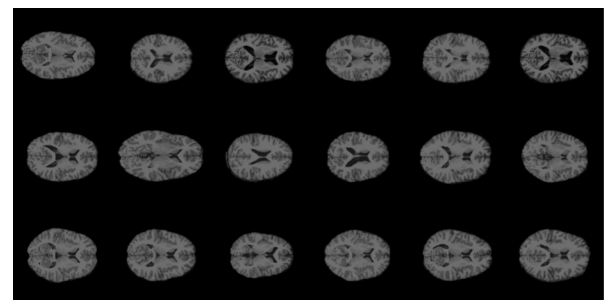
T1-weighted image (T1-weighted FLASH, TR = 12 ms; TE = 5.6 ms; 1 mm³ resolution).
